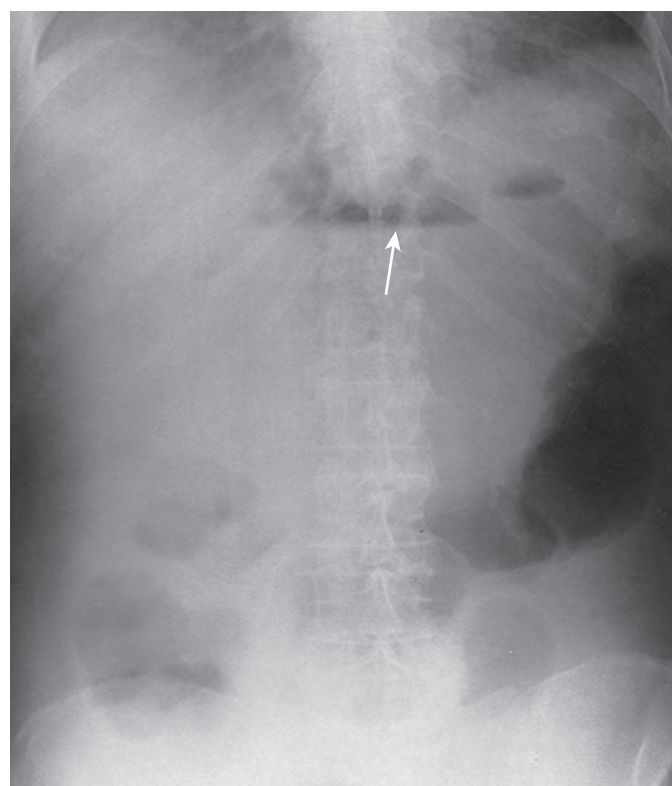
Lesser sac abscess caused by a perforated gastric ulcer. Upright abdominal radiograph shows an air-fluid level (arrow) in the lesser sac caused by a lesser sac abscess. Subsequent study with a water-soluble contrast agent revealed a perforated posterior wall gastric ulcer with leakage of the contrast agent directly into the lesser sac.
